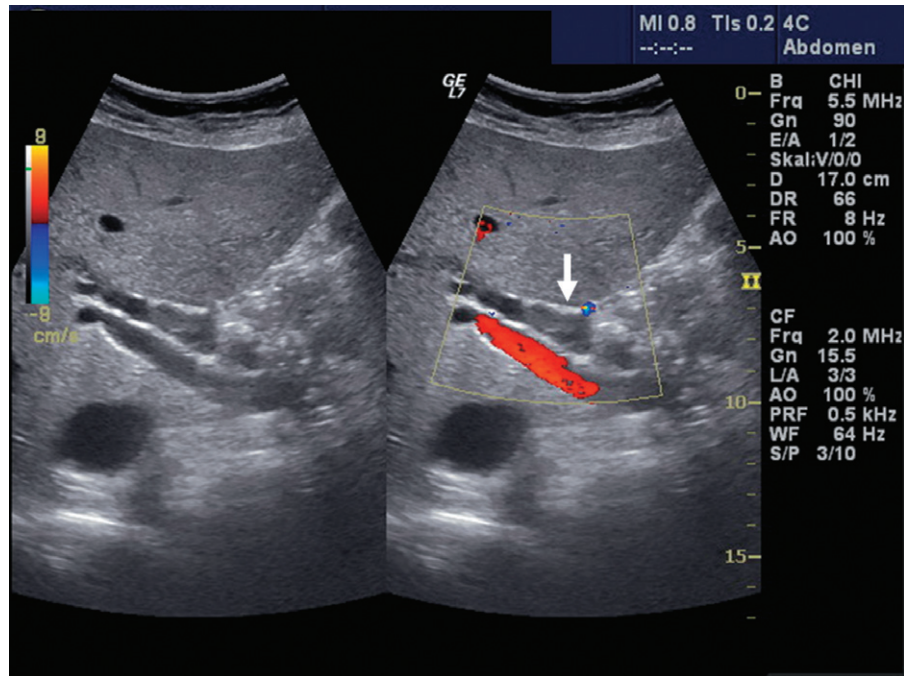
Dilated bile duct. Transabdominal ultrasound: dilated bile duct shown at liver hilus (arrow) due to an inflammatory mass of the pancreatic head in chronic pancreatitis.
